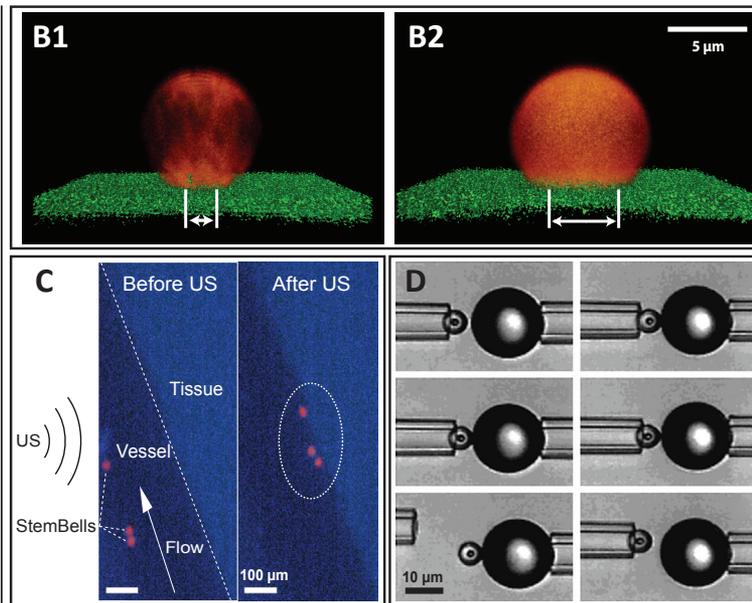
Ultrasound Molecular Imaging.
